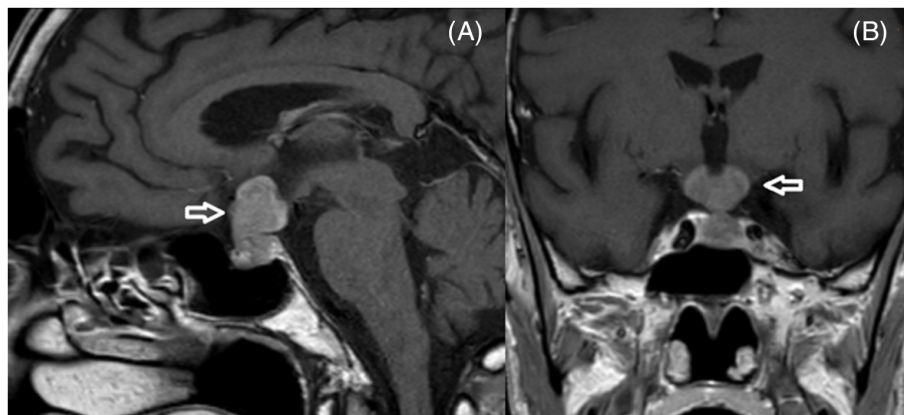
(A) Sagittal and (B) coronal MRI on T1-weighted images with gadolinium showing an intrasellar mass with suprasellar extension
